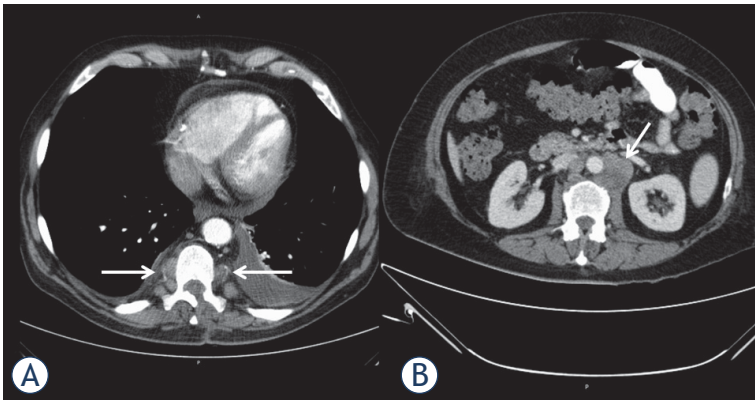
Computed tomography of the thorax (A) and abdomen in portal venous phase (B) in a 54-years old patient with acute myeloid leukemia documenting multiple paravertebral and retroperitoneal enhancing masses (arrows). Additionally, pleural and pericardial effusions are seen.
